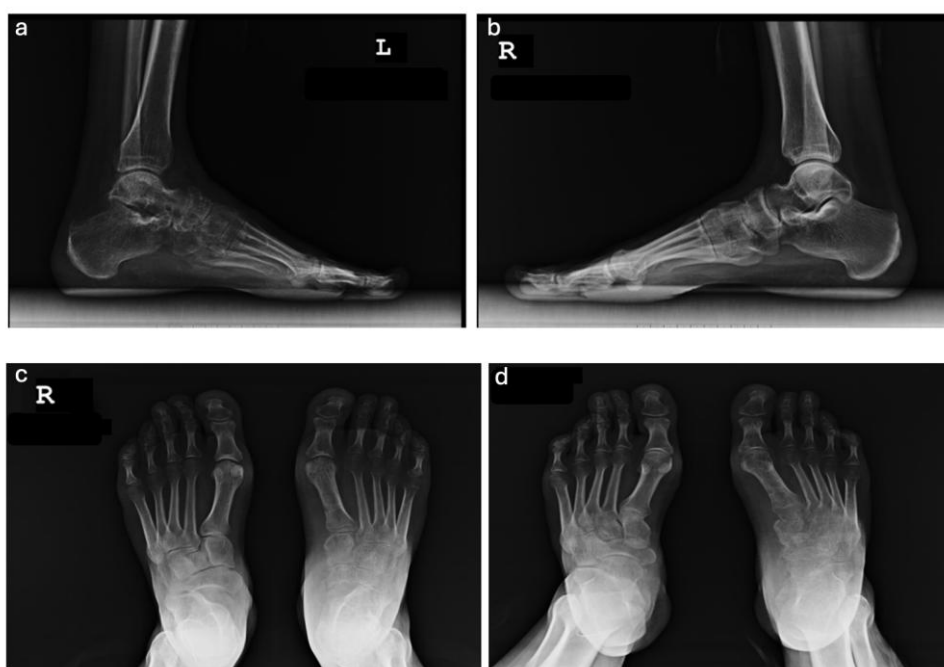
Bilateral Foot AP and Lateral Radiography After Surgical Removal of Hardware (a, b and c: weight bearing; d: non- weight bearing).
